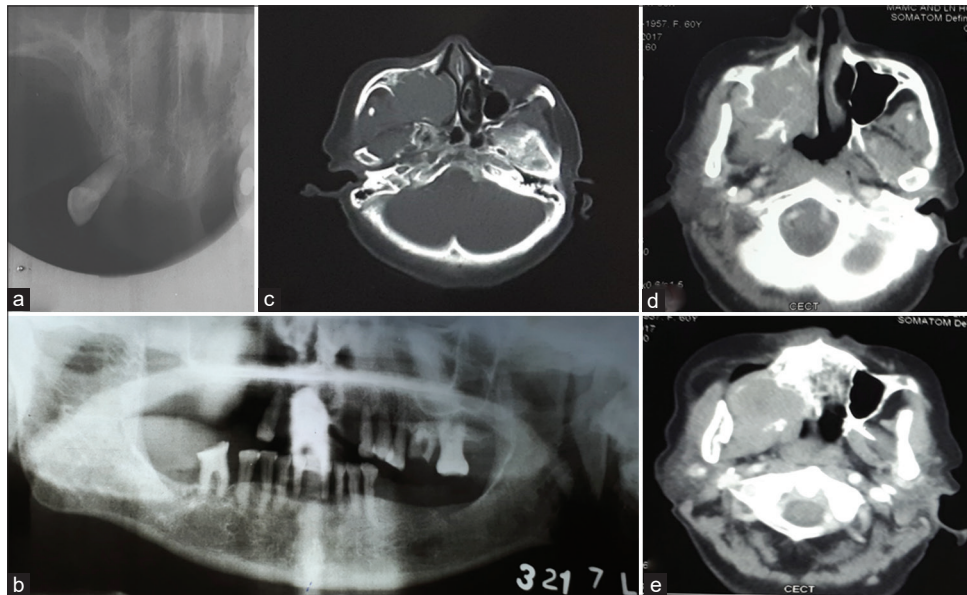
(a) Maxillary occlusal radiograph showing ill-defined radiolucency with soft-tissue density involving the right hard palate with severe bone loss mesial and distal to 13, (b) panoramic radiograph showing ill-defined radiolucency in the right maxillary region extending upwards in maxillary sinus region, (c-e) axial contrast-enhanced computerized tomography sections showing heterogeneously enhancing soft-tissue mass lesion of 5 × 5 × 4.5 cm involving right hard palate and alveolar process of maxilla extending into the right maxillary sinus, nasal cavity, and infratemporal fossae causing thinning of pterygoid plates
